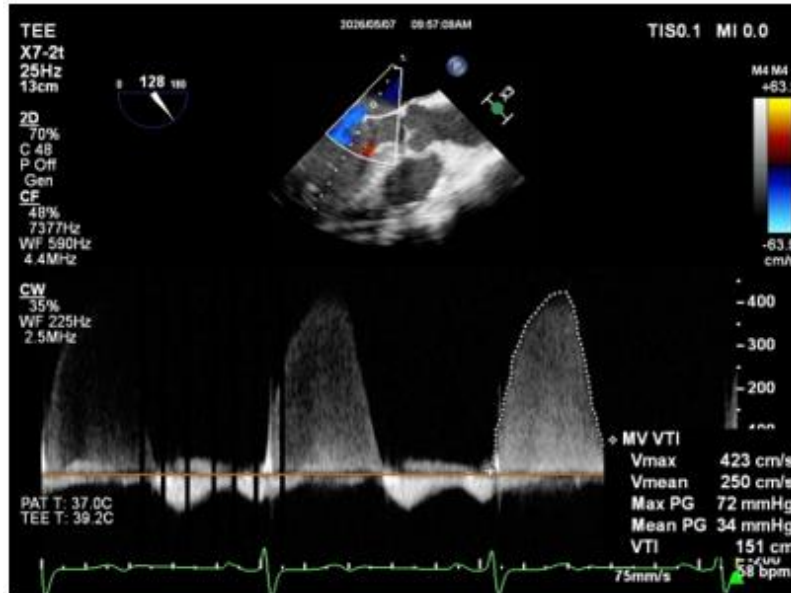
Baseline intraoperative transesophageal echocardiography (TEE) in Case 2. Continuous-wave Doppler measurement of moderate functional mitral regurgitation before cardiopulmonary bypass
